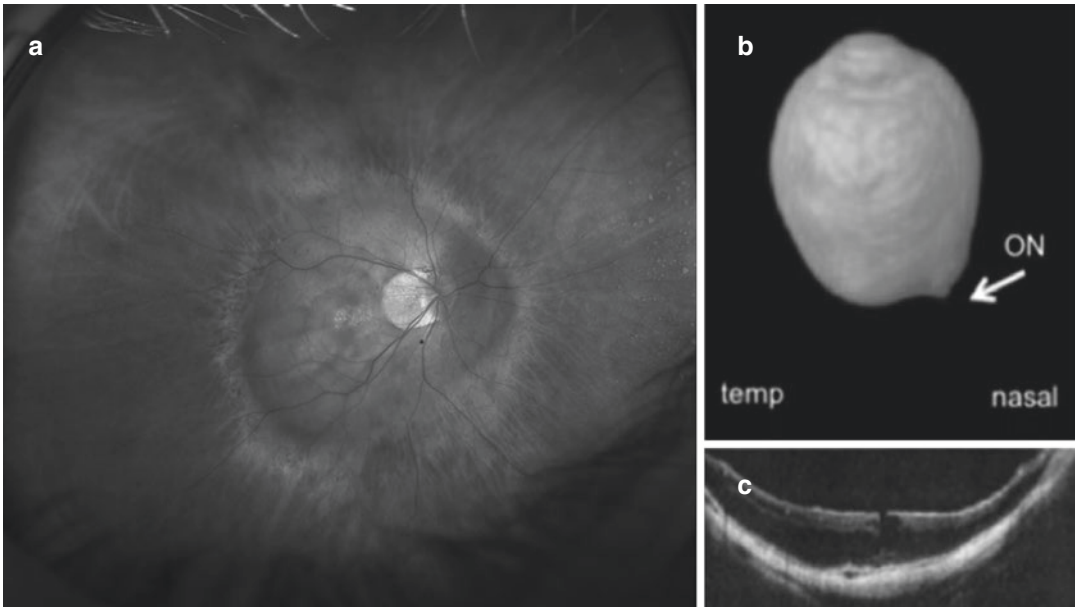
Eye affected by outer maculoschisis. (a) Wide field IR image showing a Type 1 Staphyloma involving the posterior pole. (b) MRI imaging showing the whole
